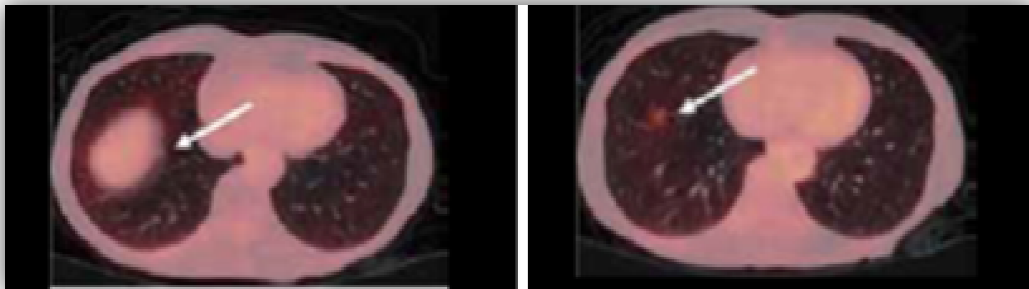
Images from a PET/CT examination of a patient that experienced an irregular respiration pattern, resulting in a mismatch between the CT and PET images. The lesion is seen close to the liver during the CT scan (image on the left), but later the PET positive focus appears to have moved in the cranial direction (image on the right) (5).
